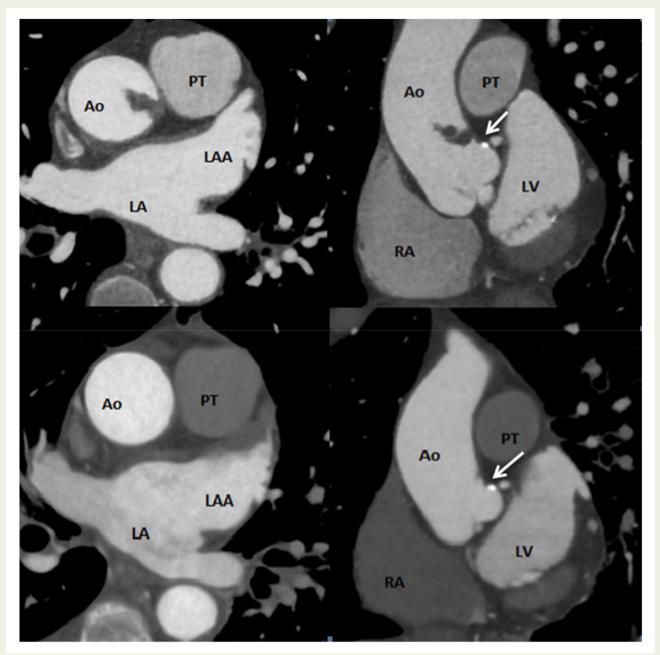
Initial (top) and 3-month follow-up (bottom) computed tomography angiography showing complete regression of the aortic thrombus with persistence of a partially calcified atheromatous plaque (arrow).
